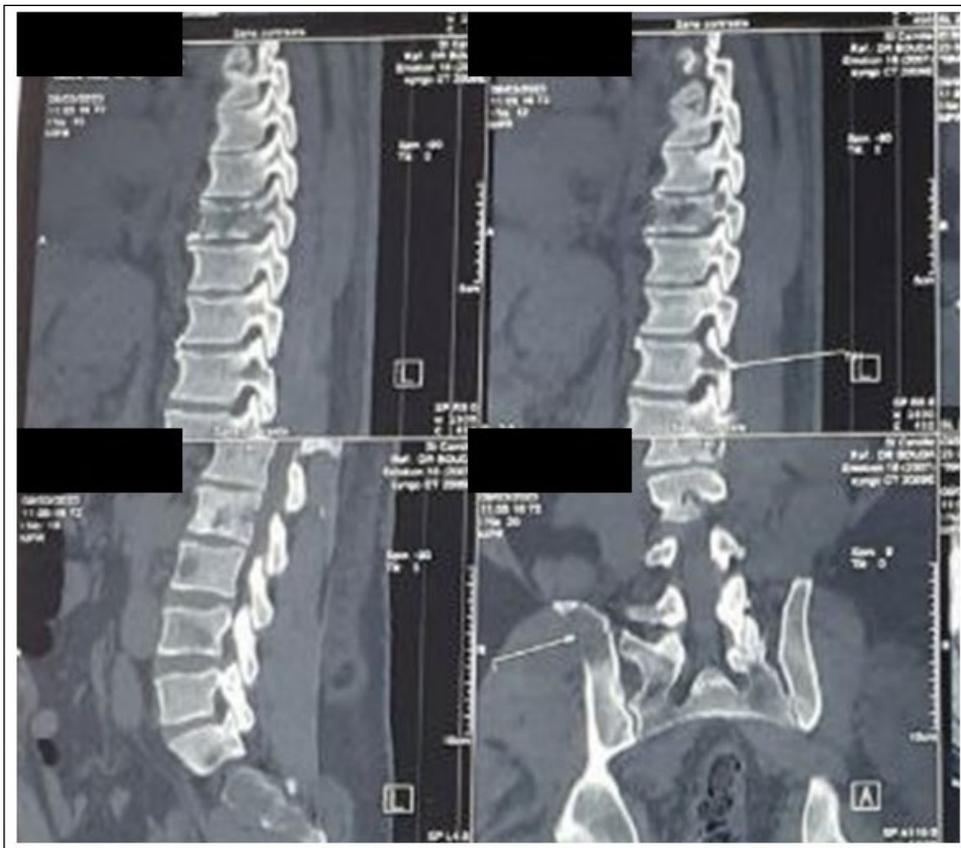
CT scan of the spine showing osteolytic lesions of the vertebrae and pelvis.
